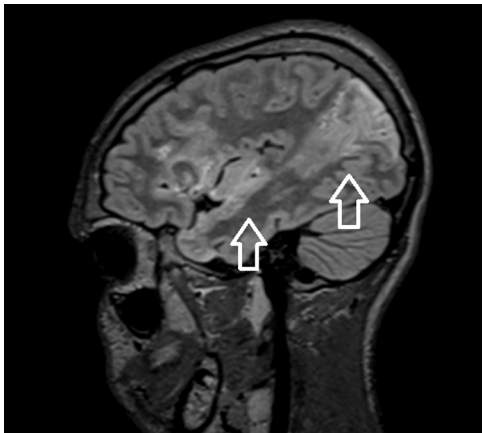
Sagittal 3D-FLAIR image showing the extent of the ischemic stroke (white arrow).
